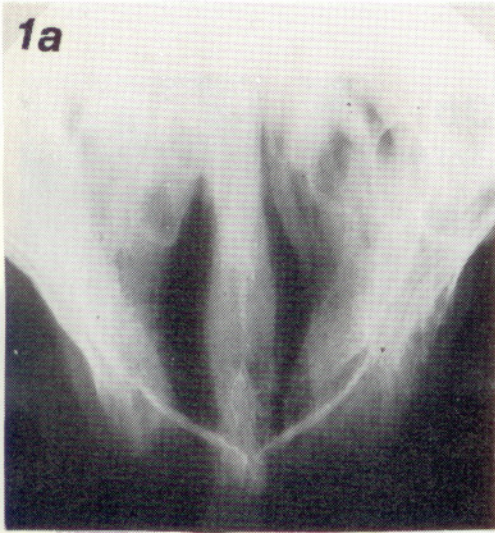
"Antemortem" radiograph. Fig. 1b "Postmortem" radiograph. No errors were made by the observers in this case. The projections and the contrast are very similar on the radiographs taken in 1975 and in 1985.
